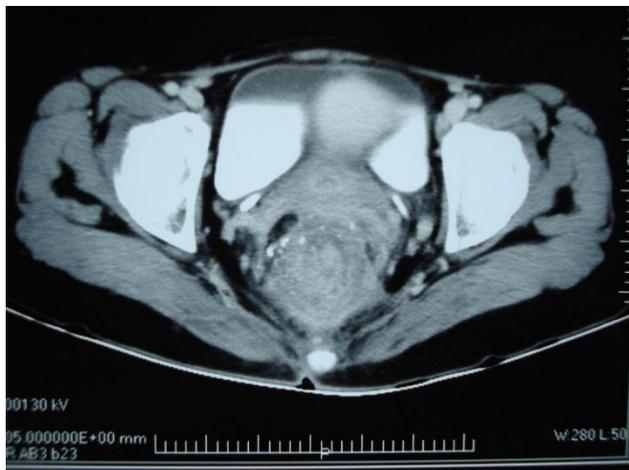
Contrast-Enhanced CT Pelvis Showing Eccentric Thickening of Rectum with Heterogenous Enhancement and Multiple Calcific Foci- Mucinous Carcinoma
